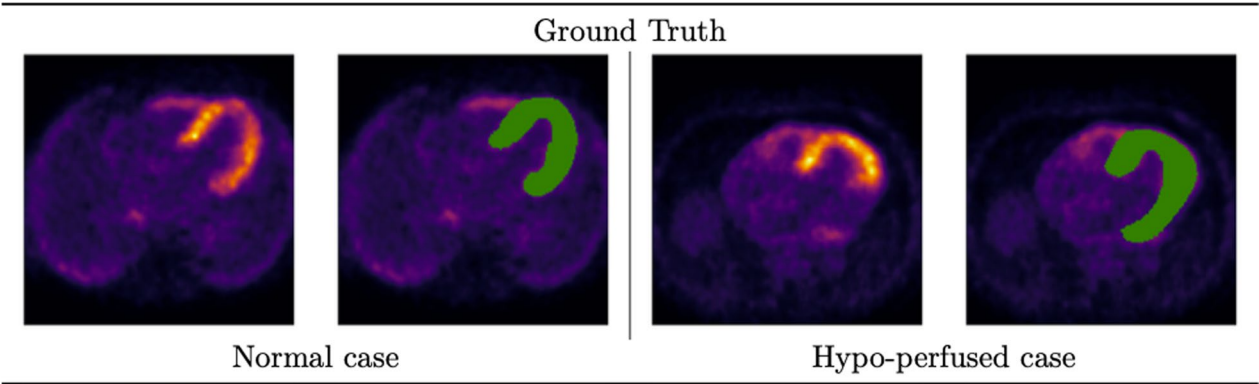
Representative manual ground-truth LV masks on ⁸²Rb PET/CT. Late PET frames with maximum myocardial uptake were used for contour delineation, while early frames helped discriminate blood pool from myocardium
